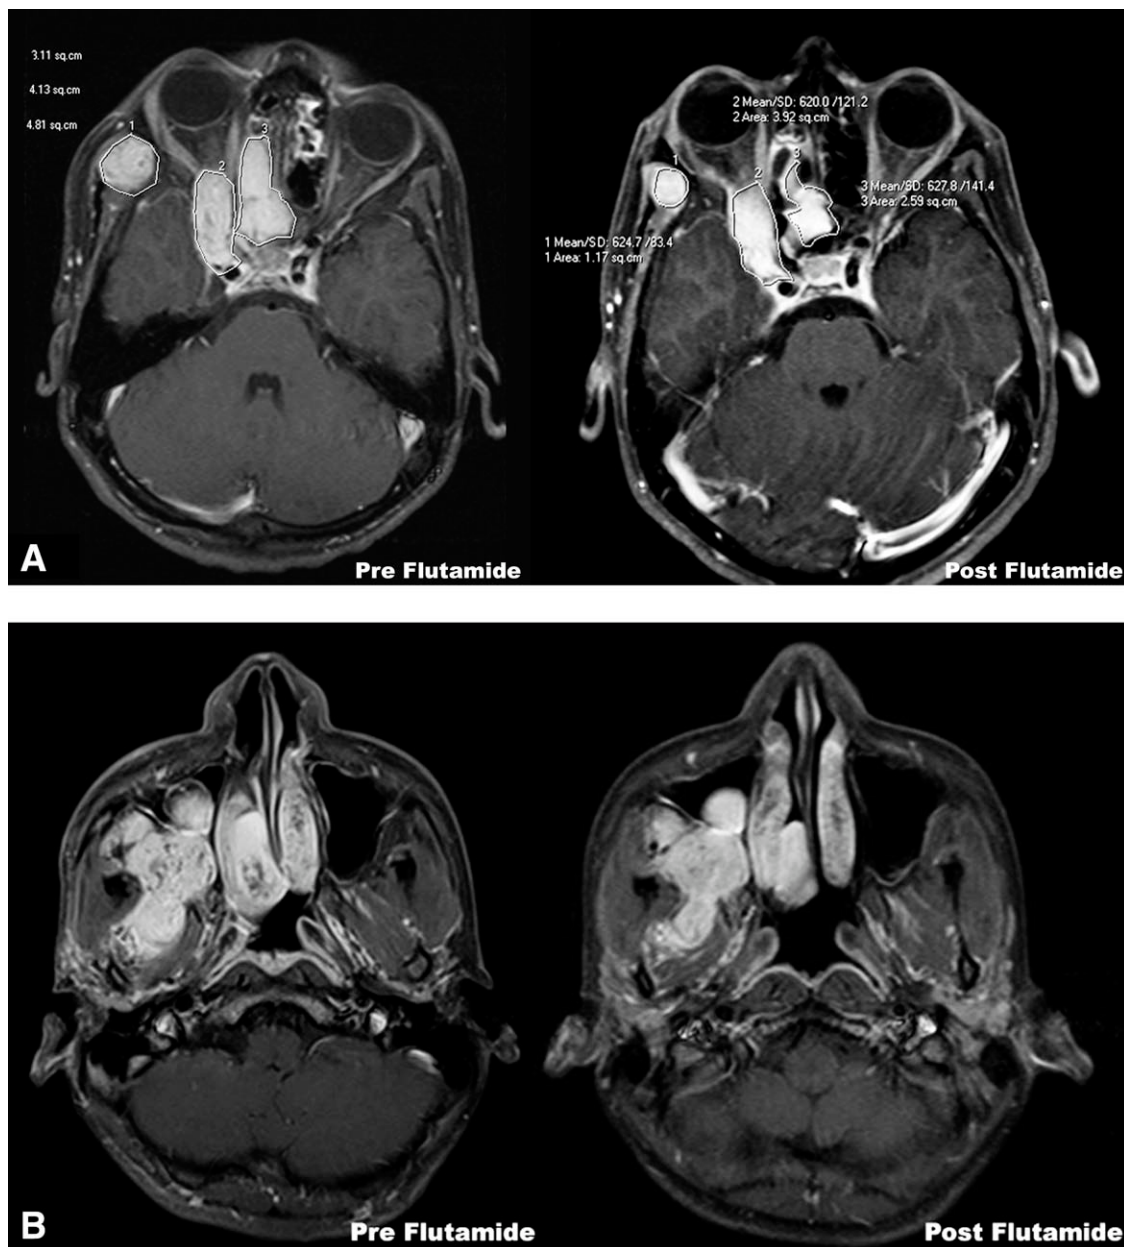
(A) Pre- and postflutamide axial MR images (stage IIIB juvenile nasopharyngeal angiofibroma [JNA], scans at level of internal carotid artery). Postflutamide tumor regression is noted in the ethmoids, temporal fossa, superior orbital fissure, and middle cranial fossa. (B) Pre- and postflutamide axial MR images (stage IIC JNA, scans at level of fossa of Rosenmüller). Postflutamide tumor regression is noted in the posterior nose and the infratemporal fossa.
